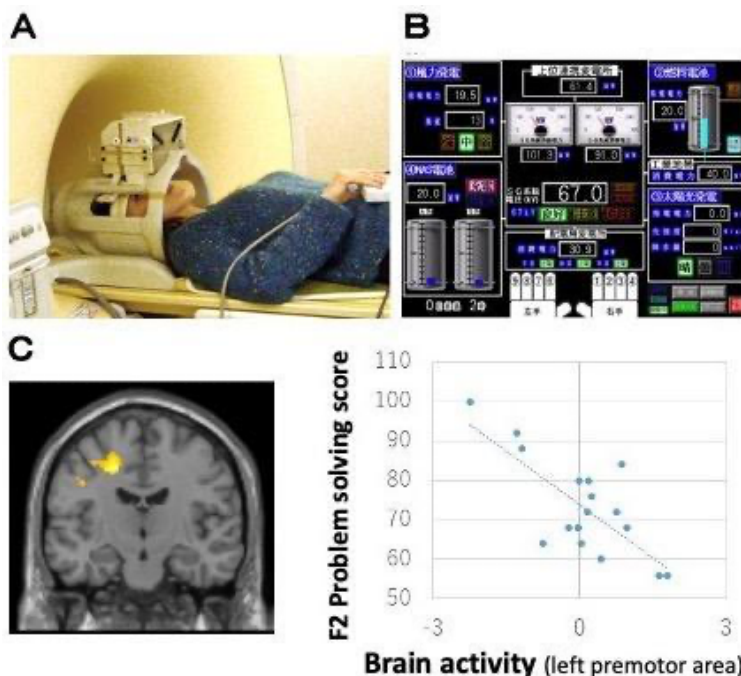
Example of brain science research on the power to live with disasters. Using magnetic resonance imaging (MRI) (A), brain activity was measured during a task of coping with an unexpected situation (B), and brain activity in the left premotor cortex was negatively correlated with F2 problem-solving scores in (C) (Miura et al., 2020).
